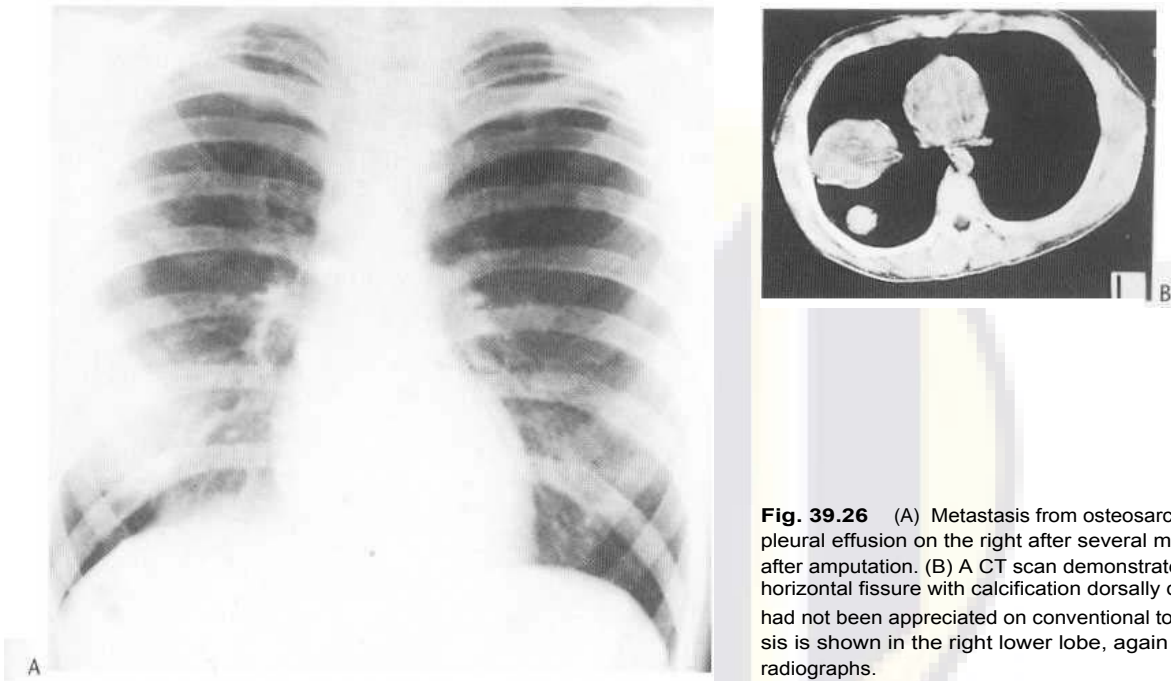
(A) Metastasis from osteosarcoma presents with an encysted pleural effusion on the right after several months apparently disease free after amputation. (B) A CT scan demonstrates the encysted effusion in the horizontal fissure with calcification dorsally due to metastasis. This feature had not been appreciated on conventional tomography. A second metastasis is shown in the right lower lobe, again not obvious on conventional radiographs.
